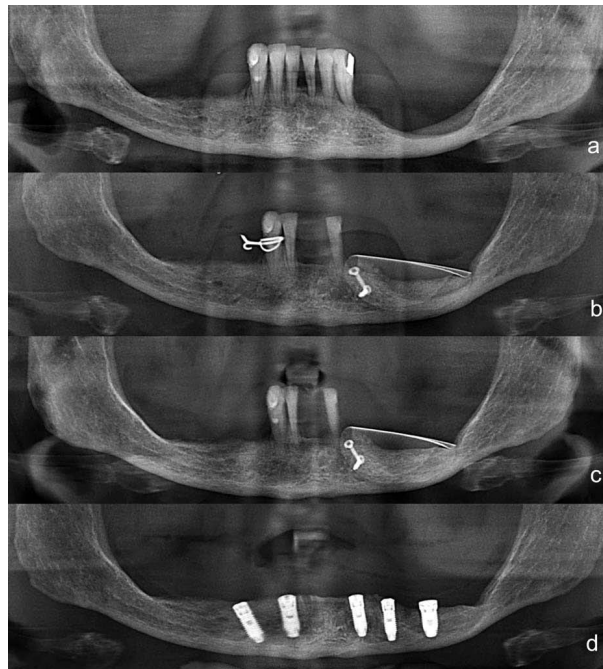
Panoramic X-rays: a) preoperative: severe bone atrophy was identified, in particular on the left side; b) four months postoperatively: the graft is collapsed; c) eleven months postoperatively: the graft seems integrated; d) immediately after the implant placement.
